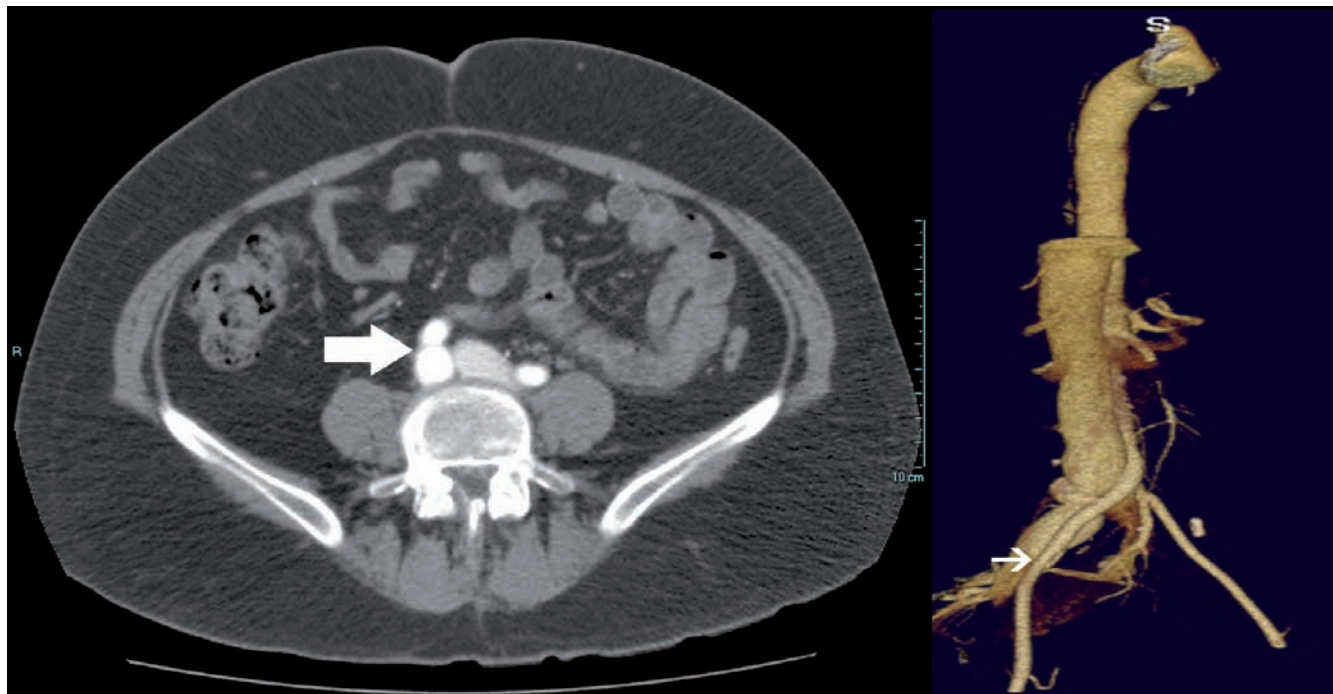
Arterial phase computed tomography demonstrating simultaneous contrast enhancement of both the common iliac arteries and the right common iliac vein (large arrow, left hand image) and 3-dimensional reconstruction demonstrating site of arterio-venous fistula (small arrow, right hand image).
